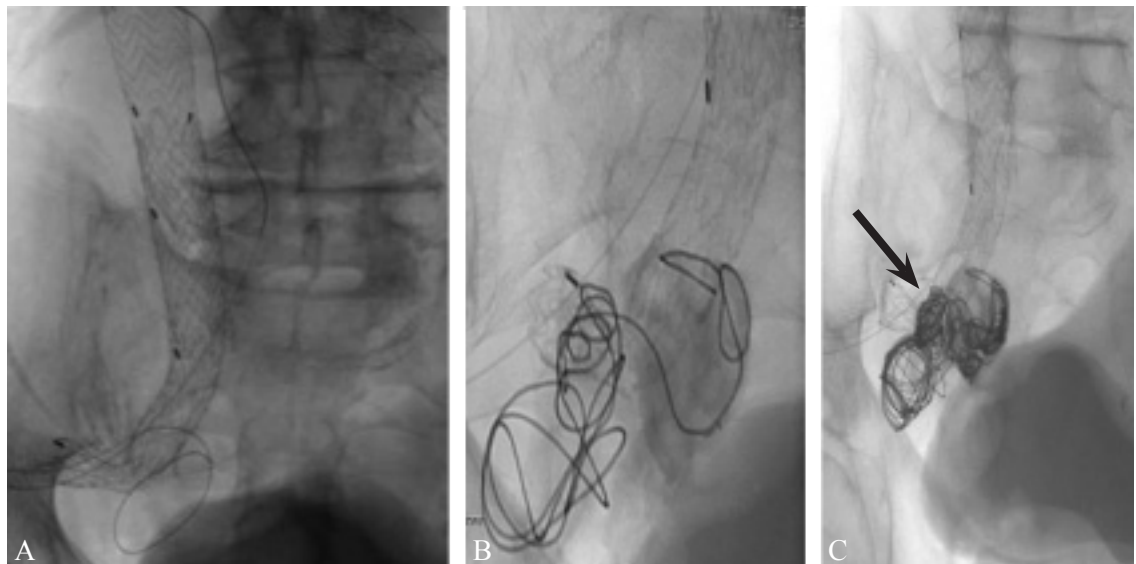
Percutaneous retrograde embolization from superior gluteal artery for a type II endoleak. A) Under CT guidance the superior gluteal arterial was punctured and a 0.018” inch guide wire was advanced (arrow). Note a second wire (arrow-head) which was deliberately inserted in the superior gluteal vein and was left in situ as reference. B, C) After the catheterization of the aneurysm sac with a 2.7-Fr microcatheter (Progreat, Terumo Corp.), two 7×40-mm and 6×30-mm detachable coils (Ruby, Penumbra) were deployed.
